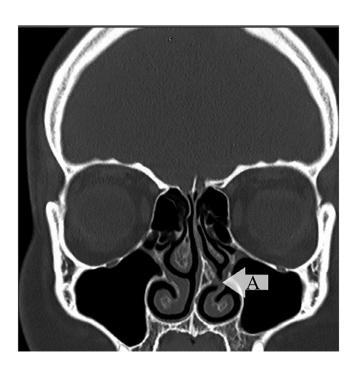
Fixed MCP On CT sinus (arrow). MCP, mucosal contact point
